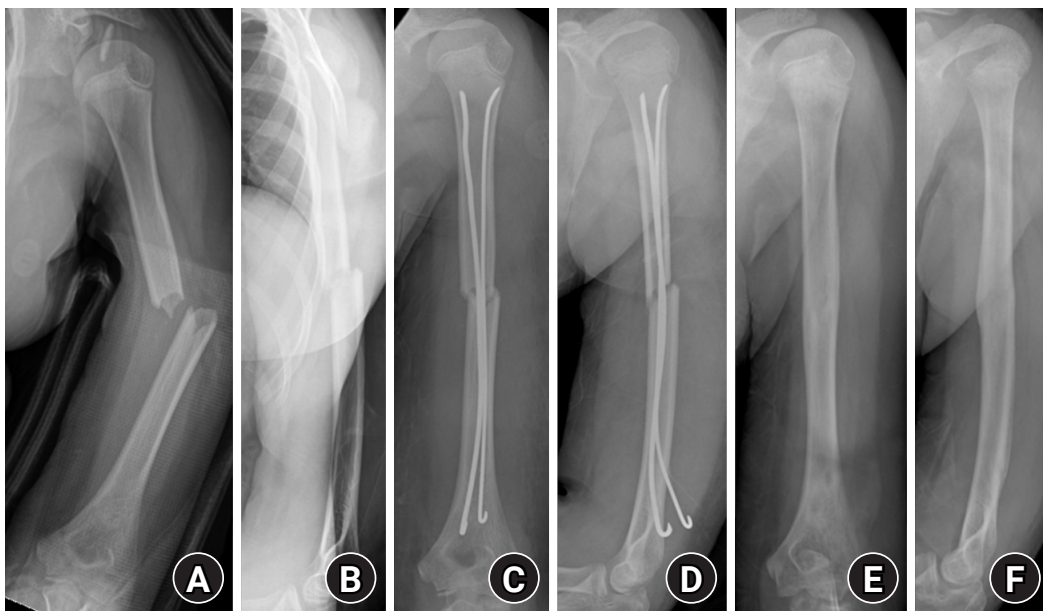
Radiographs of a representative case demonstrating successful bone healing following elastic stable intramedullary nailing fixation. (A, B) Preoperative anteroposterior and lateral radiographs showing a midshaft humeral fracture. (C, D) Immediate postoperative radiographs demonstrating satisfactory fracture alignment and stable fixation with elastic nails. (E, F) Follow-up radiographs obtained after implant removal showing complete bone union and restoration of normal humeral alignment.
